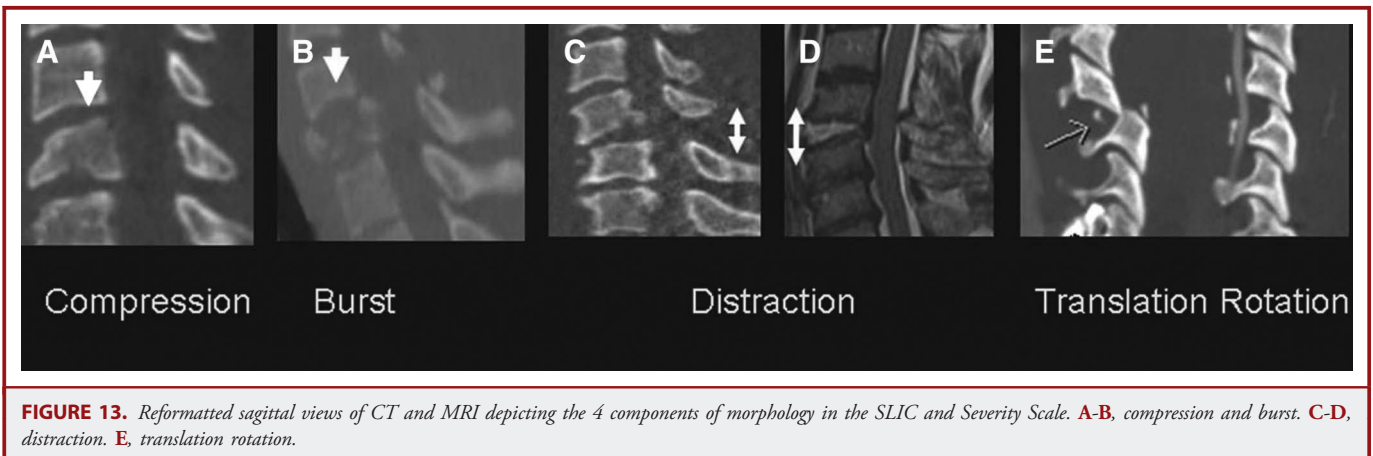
Reformatted sagittal views of CT and MRI depicting the 4 components of morphology in the SLIC and Severity Scale. A-B, compression and burst. C-D, distraction. E, translation rotation.
